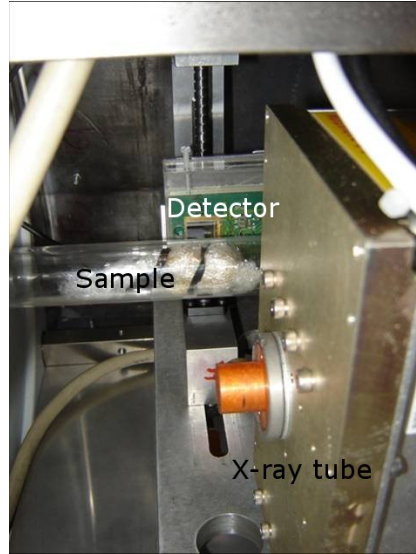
Photograph of the interior of the scanner 'MARS-1' with detector, sample and x-ray tube labelled.
